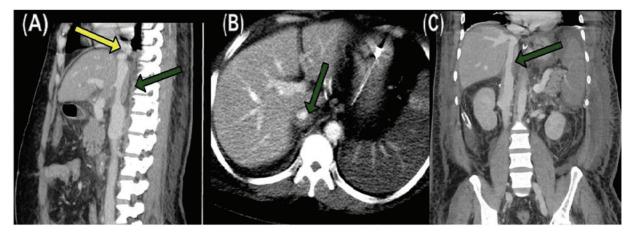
A 48-year-old male patient who underwent orthotopic liver transplantation had high urine output with deranged renal parameters on 6th postoperative day (POD). Contrast-enhanced computed tomography (CECT) sagittal images of the upper abdomen shows focal critical stenosis (A, yellow arrow) in the superior aspect of inferior vena cava (IVC). Axial and coronal images of the same patient show eccentric hypodense nonocclusive filling defect in IVC (B and C, green arrow)—consistent with partial IVC thrombosis.
